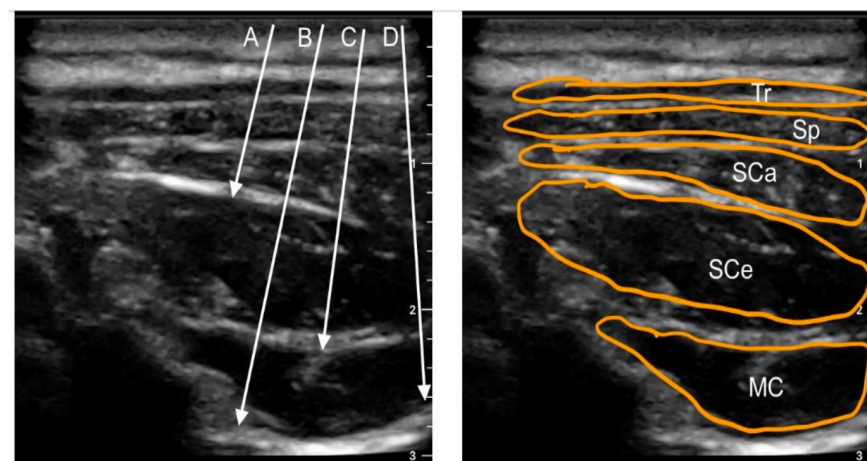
Transverse sonogram of the posterior neck area at the C5 level. The arrows indicate the needle trajectories for: A—inter-semispinal plane block; B—retrolaminar cervical block; C—multifidus cervicis plane block; D—cervical erector spinae plane block. MC—multifidus cervicis muscle; SCe—semispinalis cervicis muscle; SCa—semispinalis capitis muscle; Sp—splenius muscle; Tr—trapezius muscle.
